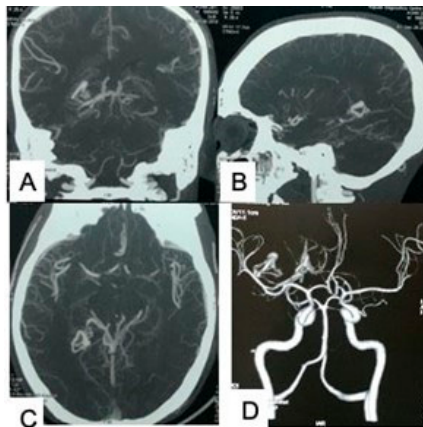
(A–D) CT angiogram showing a posterior medial temporal AVM fed by branches from the posterior cerebral artery and venous drainage toward the deep venous system. Source: Figure by authors.
